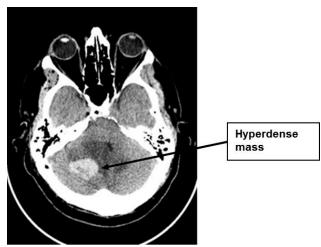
CT of the brain from a 63 year old man who presented with intractable nausea and vomiting demonstrates a hyperdense mass in the right cerebellum. Differential diagnoses include hematoma, hemorrhagic infarct, or neoplasm. University of Massachusetts Medical School, Department of Radiology
